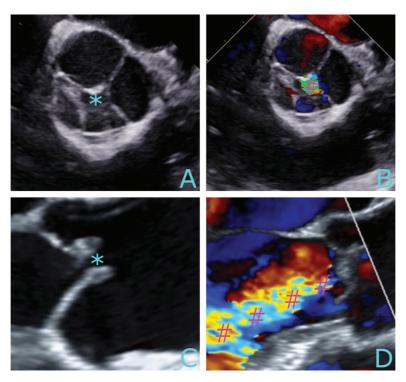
Echocardiographic findings. Case 1 (A, B): short axis of the AV in transesophageal echocardiography. Case 2 (C, D): long axis of the left ventricular outflow tract, aortic valve, and root in transesophageal echocardiography. Pictures A and C show brightness mode of the AV without central coaptation (*). Pictures B, and D display the regurgitation jet (#) in a color Doppler mode.
